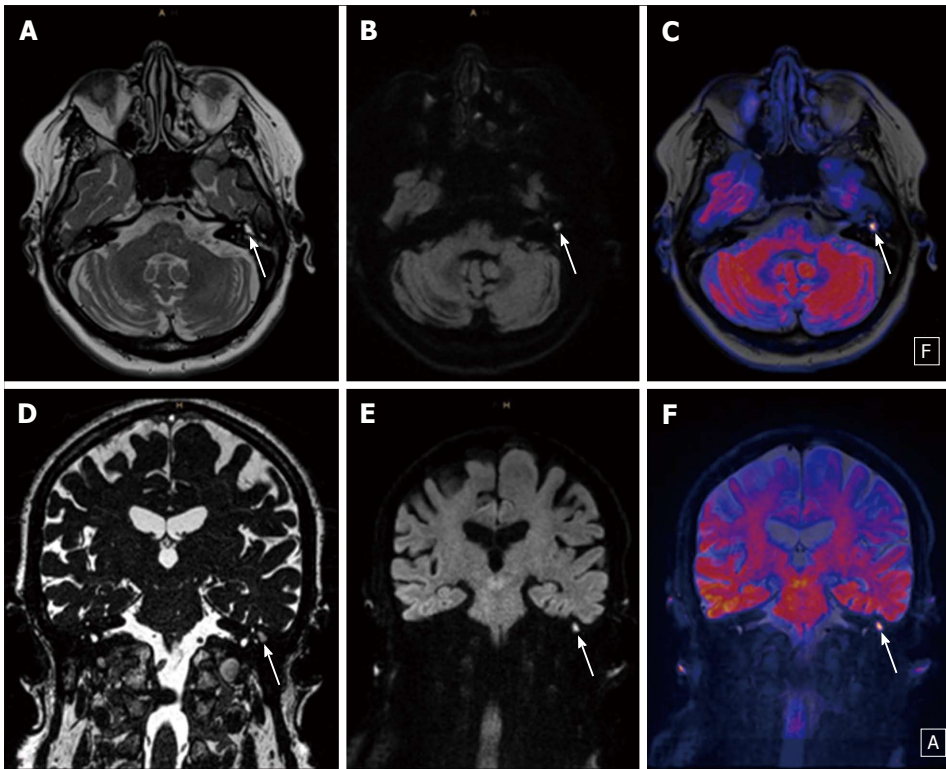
Twenty-three-year-old male patient with a typical cholesteatoma detected with diffusion weighted imaging. A, D: T2 weighted images (A and D) show a fluid-like mass in the left middle ear (white arrow); B, C, E, F: EPI DWI RESOLVE (B and E) depict a hyperintense signal (white arrow) consistent with restriction due to a small cholesteatoma that is better demonstrated on fused images (C and F). DWI: Diffusion weighted imaging; EPI: Echo-planar imaging; RESOLVE: Readout-segmented echo-planar.
